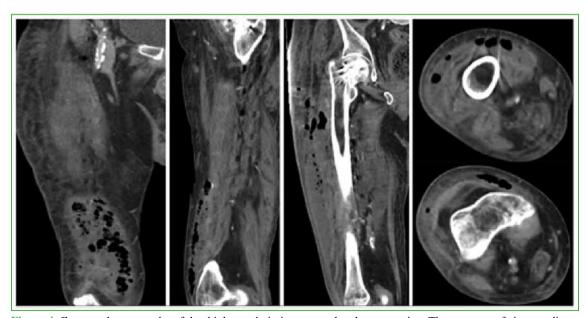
Computed tomography of the thigh on admission, coronal and cross section. The presence of air extending below the fascia is confirmed.
